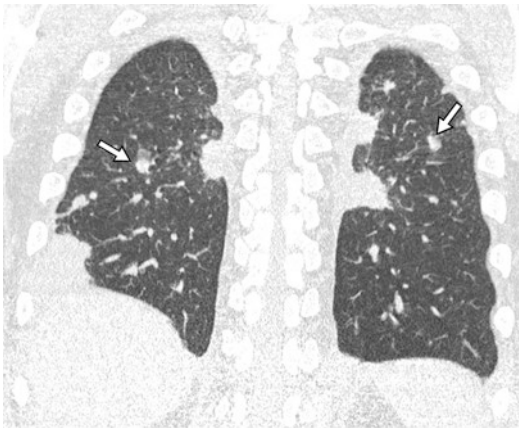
Posttransplantation lymphoproliferative disorder (PTLD) in a 54-year-old man with refractory anemia with excess blasts. Coronal CT shows bilateral ill-defined nodular opacities (arrows)
